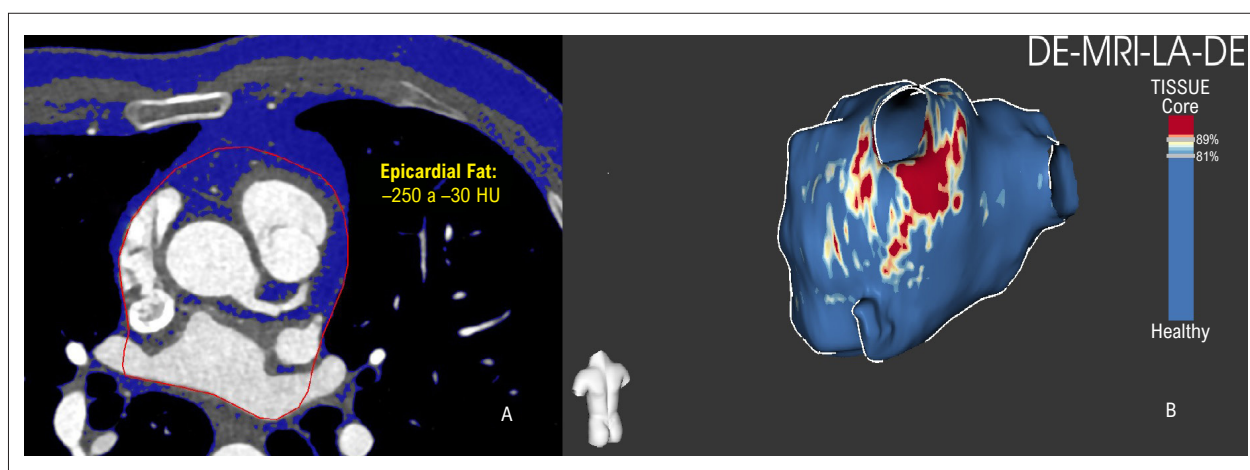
Epicardial fat (A) measured with computed tomography and left atrium fibrosis (B) measured with cardiac magnetic resonance.
